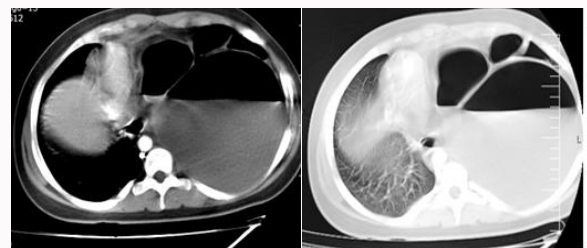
CT-scan with air-fluid collection, shift of mediastinum and septation.
